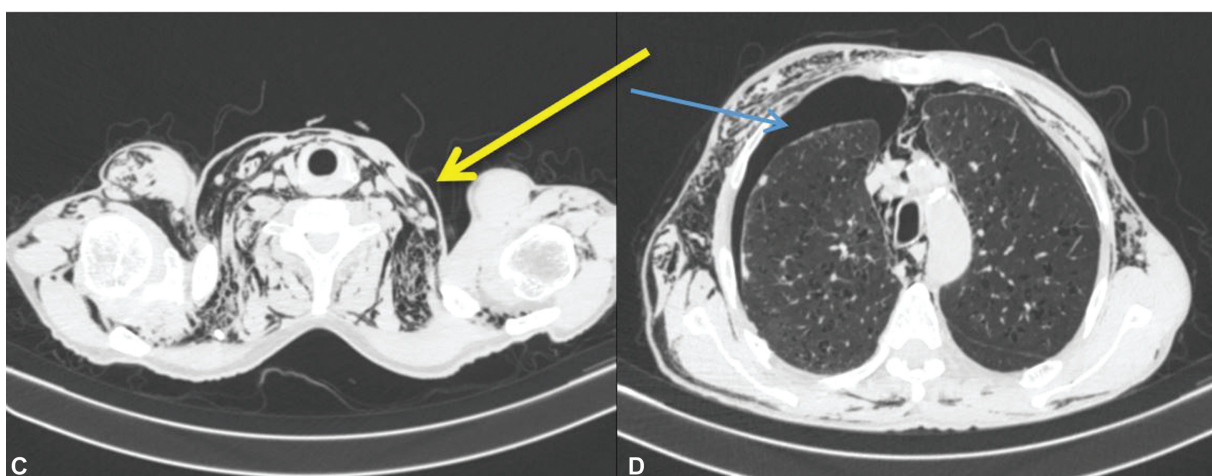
(C and D) Severe bilateral subcutaneous emphysema in the neck and thorax region with mild pneumothorax, pneumomediastinum in the CT scan (arrows) after 2 days.
